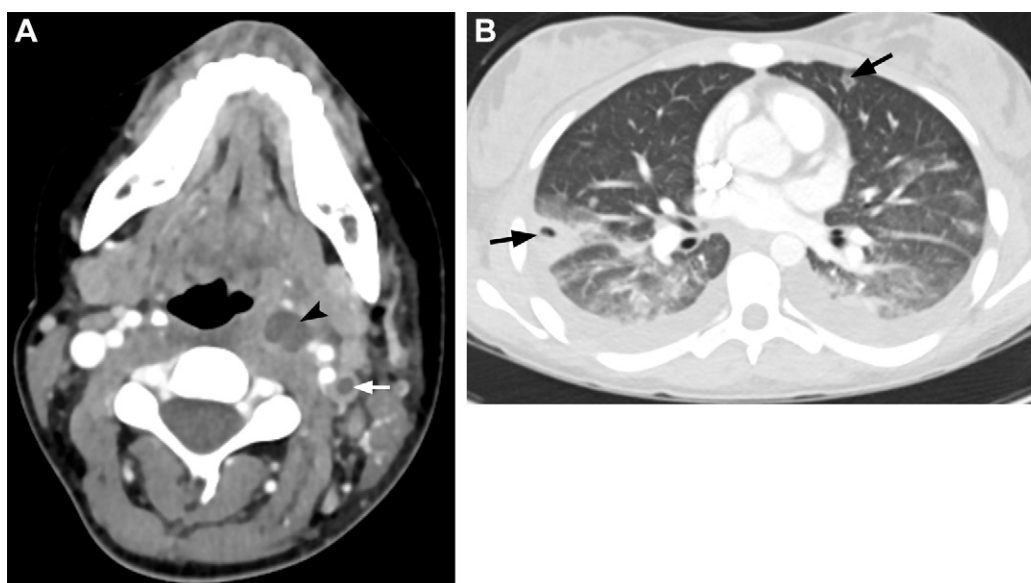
Peritonsillar abscess extending into the left parapharyngeal space complicated by Lemierre syndrome in a 17-year-old adolescent girl. (A) Axial CECT image shows a parapharyngeal space abscess (arrowhead) and nonocclusive hypoattenuating thrombus (arrow) in the left internal jugular vein. (B) Axial CT image (lung window) shows peripheral cavitary lung nodules (arrows). Lemierre syndrome can complicate any head and neck infection, and the radiologist is often the first to suspect the diagnosis.
